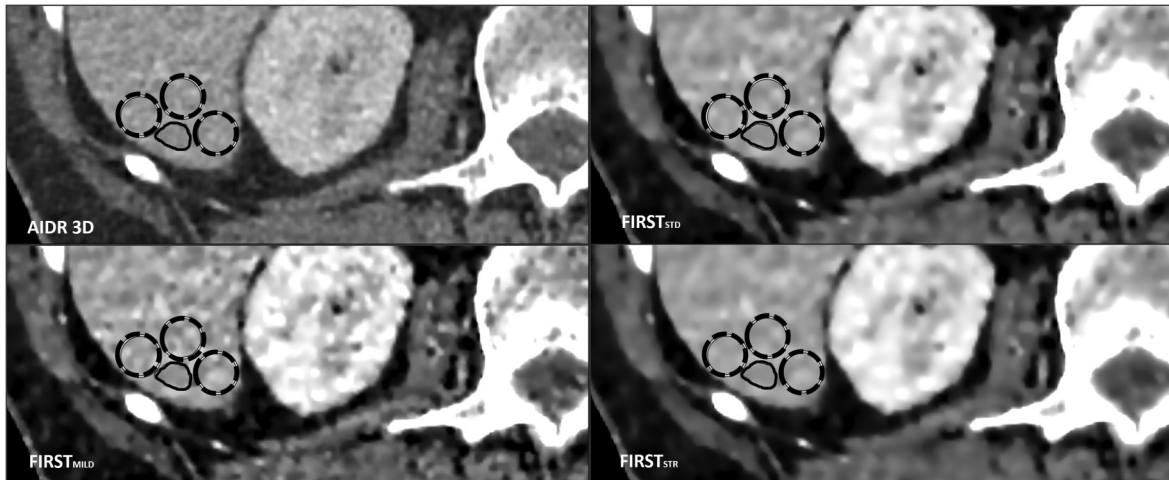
Exemplary placement of the ROI measurements in axial computed tomography images: liver ROIs (thin, continuous line) and lesion ROI (thick, dashed line) for liver-to-lesion contrast calculation. ROI, region of interest.
